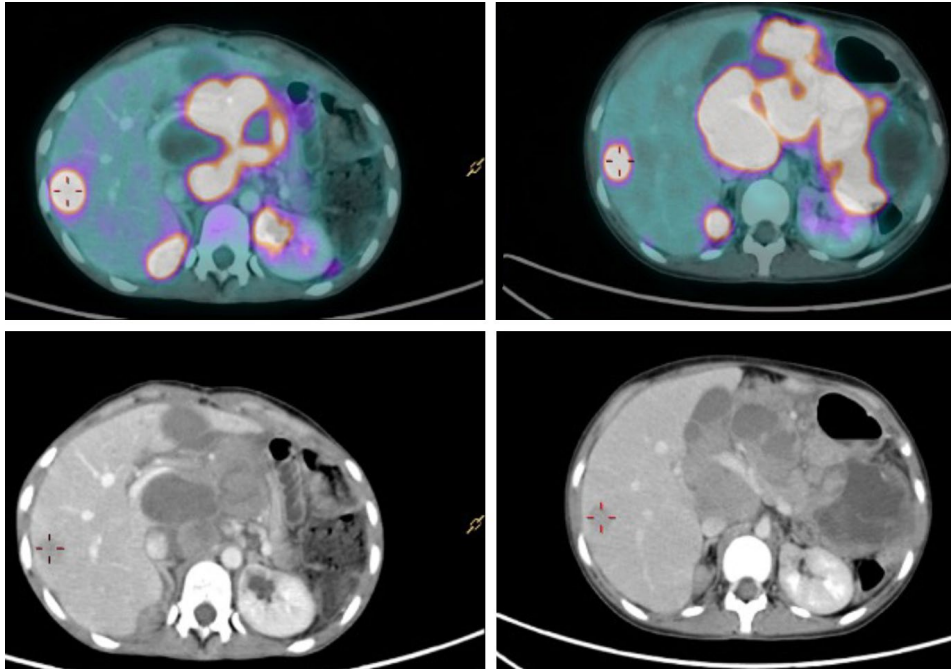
PET/CT-scan prior to surgery.
